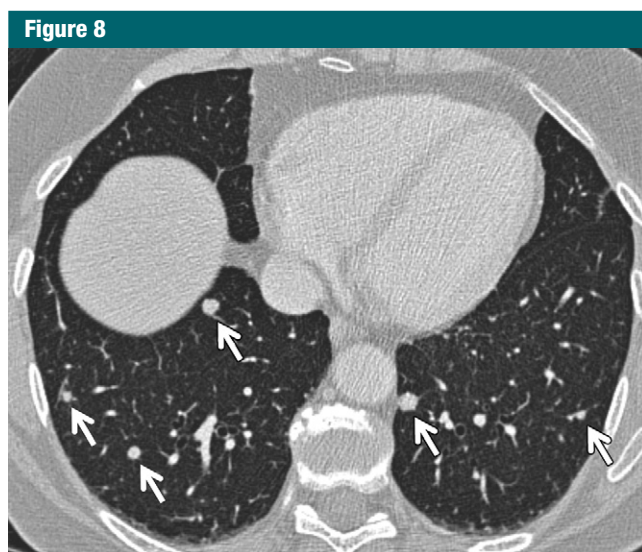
CT image shows multiple solid nodules of varying size with lower zone predominance (arrows) secondary to metastatic thyroid carcinoma.
